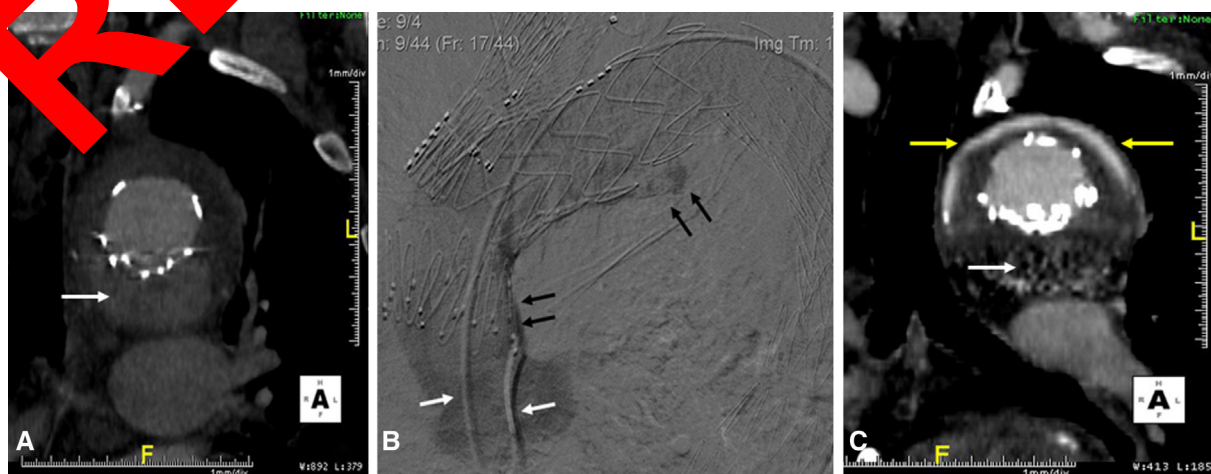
A, Computed tomographic angiography type IA endoleak caused by inadequate apposition of the proximal stent to the lesser curve of the ascending aorta shown on digital subtraction angiography (B). Contrast mixed biogluce within the aneurysm sac with no evidence of ongoing endoleak.
